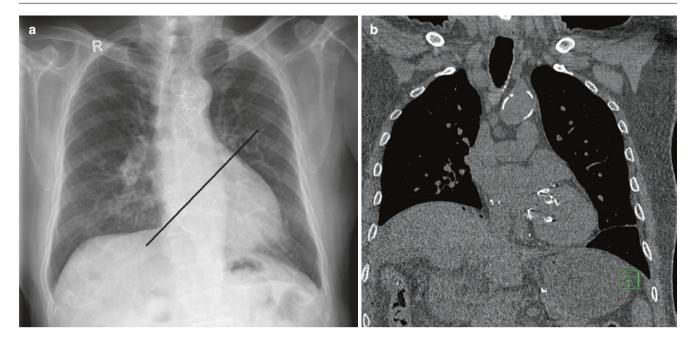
(a) Chest radiograph with line aiding differentiation of an aortic and, in this case, a mitral valve. (b) Coronal unenhanced CT of a prosthetic mitral valve
